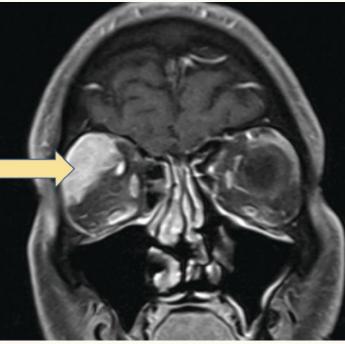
MRI with contrast demonstrating biopsy-proven B-cell NHL involving the lacrimal gland.
